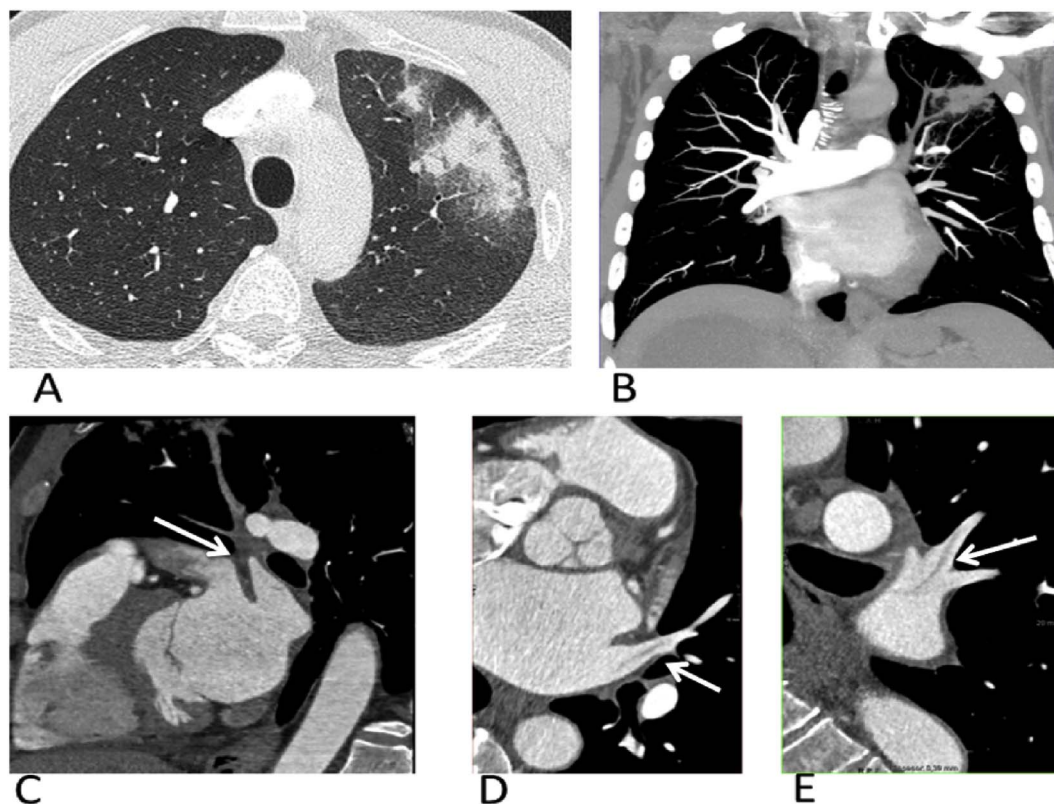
Thoracic angiography (A and B) showing extensive consolidation in the anterior segment of the LUL with a high-density central component, corresponding to lung infarction, and a low-density periphery due to hemorrhage; Cardiac CT (C, D and E) after injection of intravenous contrast in the late phase with filling defect of the left superior lobar vein (white arrow) and its subsegmental branches.
